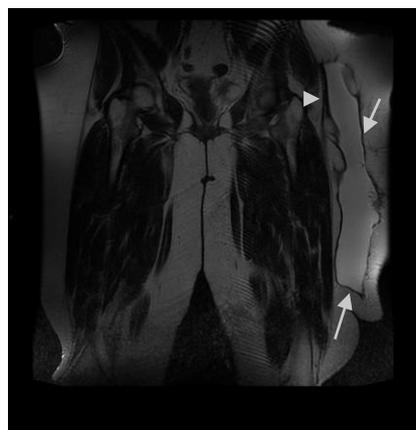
T2 weighted images in MRI with subcutaneous fluid collection (long arrows) at the upper lateral left thigh region, just overlying left iliotibial band (short arrow) with high signal intensity.
